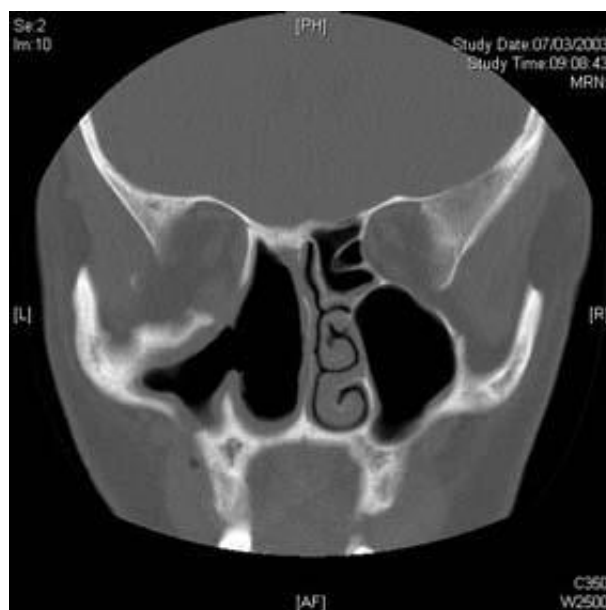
CT Scan demonstrating the extent of bony resection in a patient with woodworkers adenocarcinoma of the ethmoid sinus
